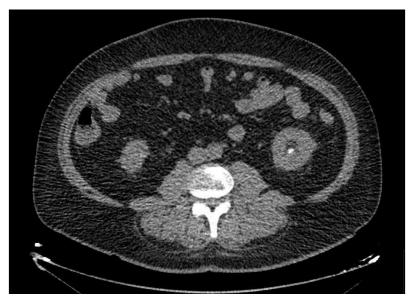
CT scan performed in February 2020
